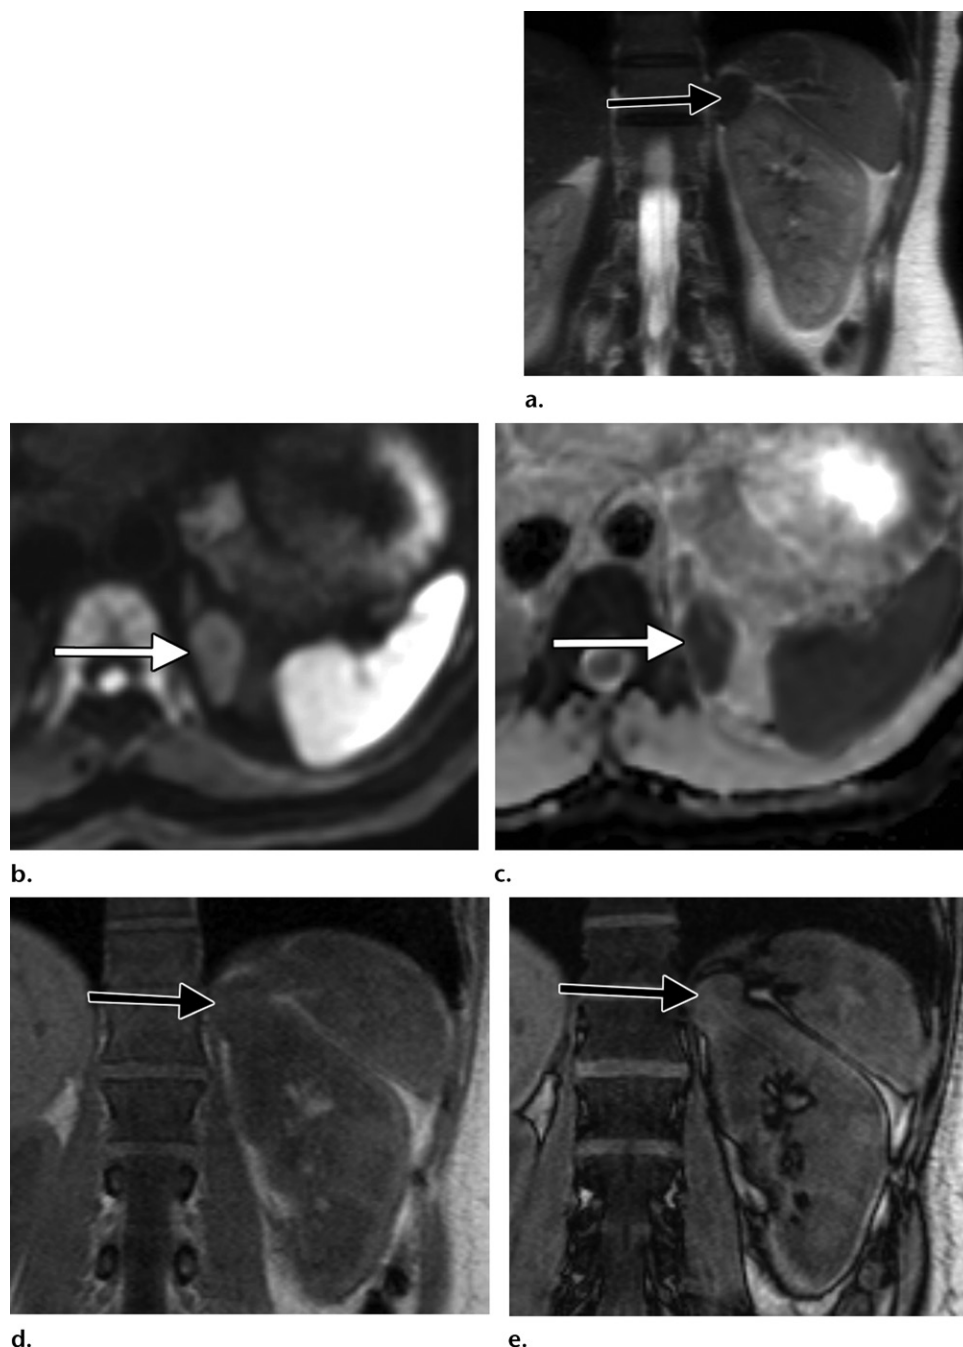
Active surveillance of a left renal mass found at chest CT in a 68-year-old man. (a–c) Coronal SSFSE T2-weighted MR image (a), axial diffusion-weighted MR image (b), and axial apparent diffusion coefficient map (c) show a partially exophytic 2.3-cm mass (arrow) in the upper pole of the left kidney, a finding that is concerning for renal malignancy or a lipid-poor angiomyolipoma. (d, e) Coronal in-phase (d) and out-of-phase (e) T1-weighted MR images show no fat component in the lesion (arrow). The lesion has remained stable since the initial CT examination.
